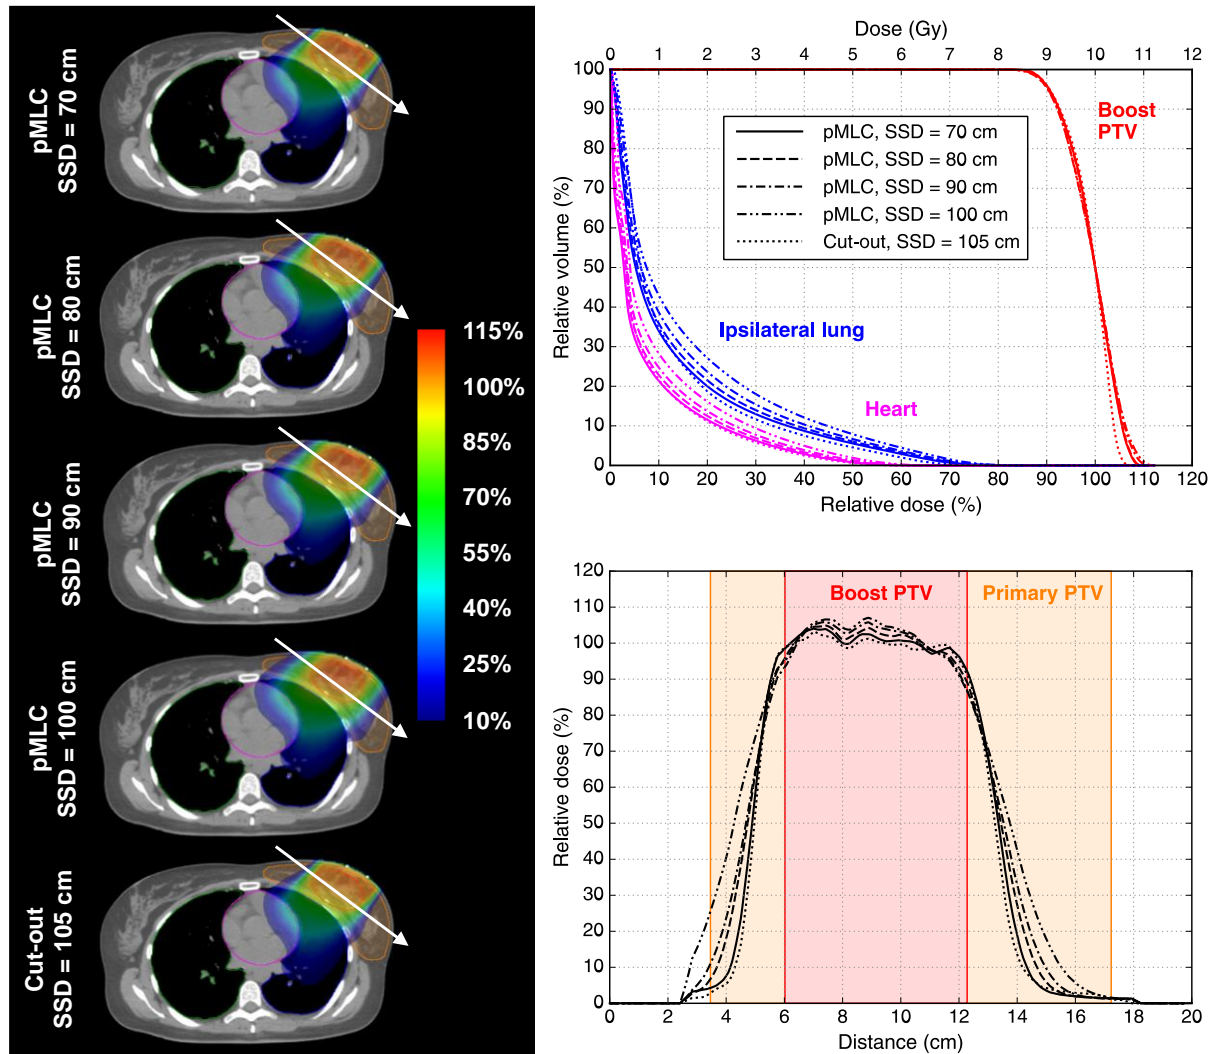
Dose distributions (left) and DVHs (top right) of TrueBeam 18 MeV 1E plans created for the left breast boost case and dose profiles (bottom right) indicated by a white arrow on the dose distributions. The legend of the DVHs also applies to the dose profiles. The contours of the boost PTV (red), primary PTV (orange), ipsilateral lung (blue), contralateral lung (green) and heart (magenta) are visible on the transversal CT images.
